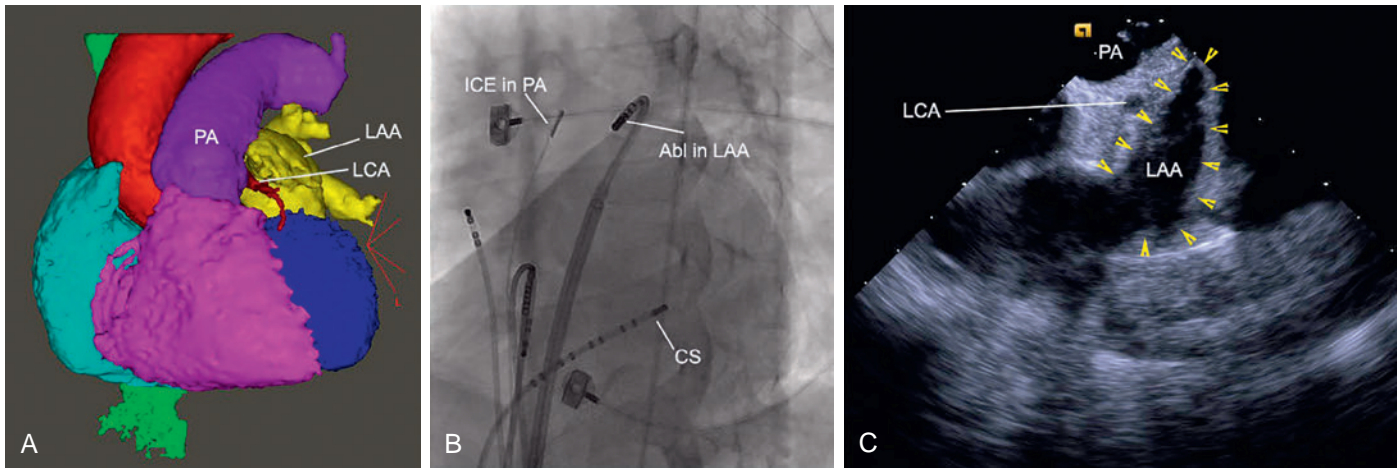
Intracardiac Echocardiography (ICE) of the Left Atrial Appendage (LAA). (A) Segmented three-dimensional cardiac computed tomography (in the left anterior oblique [LAO] projection) showing the anatomic relationship between the LAA and pulmonary artery (PA). (B) Fluoroscopic view (LAO) of the ICE transducer positioned in the PA for imaging of the LAA. The ablation catheter (*Abl*) is positioned in the LAA. (C) ICE image of the LAA (*arrowheads*) acquired with the ICE transducer position in the PA. CS, Coronary sinus; LCA, left coronary artery.
